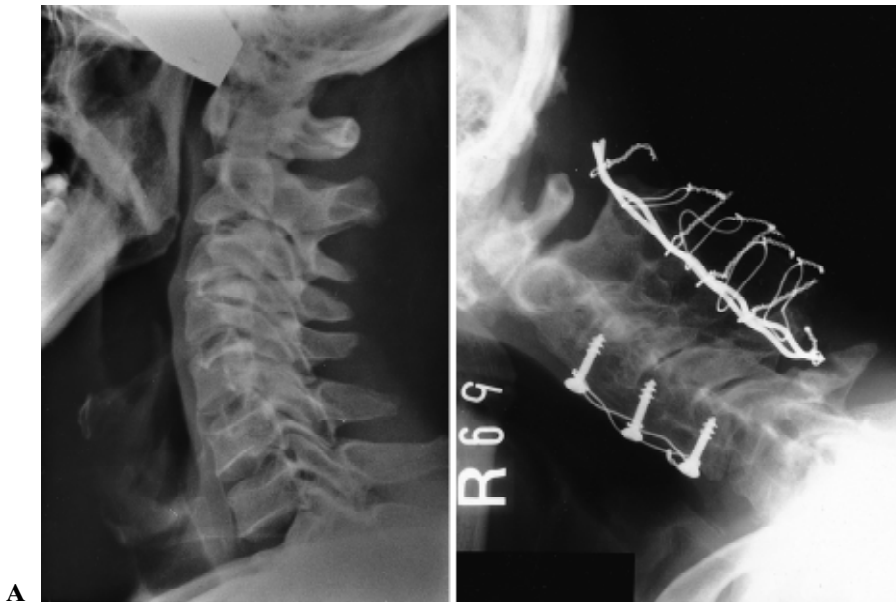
Roentgenograms in case 5. A Lateral radiograph showing cervical spondylotic changes at the third and fourth cervical levels. B Lateral radiograph in flexed position made 10 years after surgery, revealing slight atlanto-axial subluxation, complete bony union between C2 and C5, and erosion of the spinous process at C6
